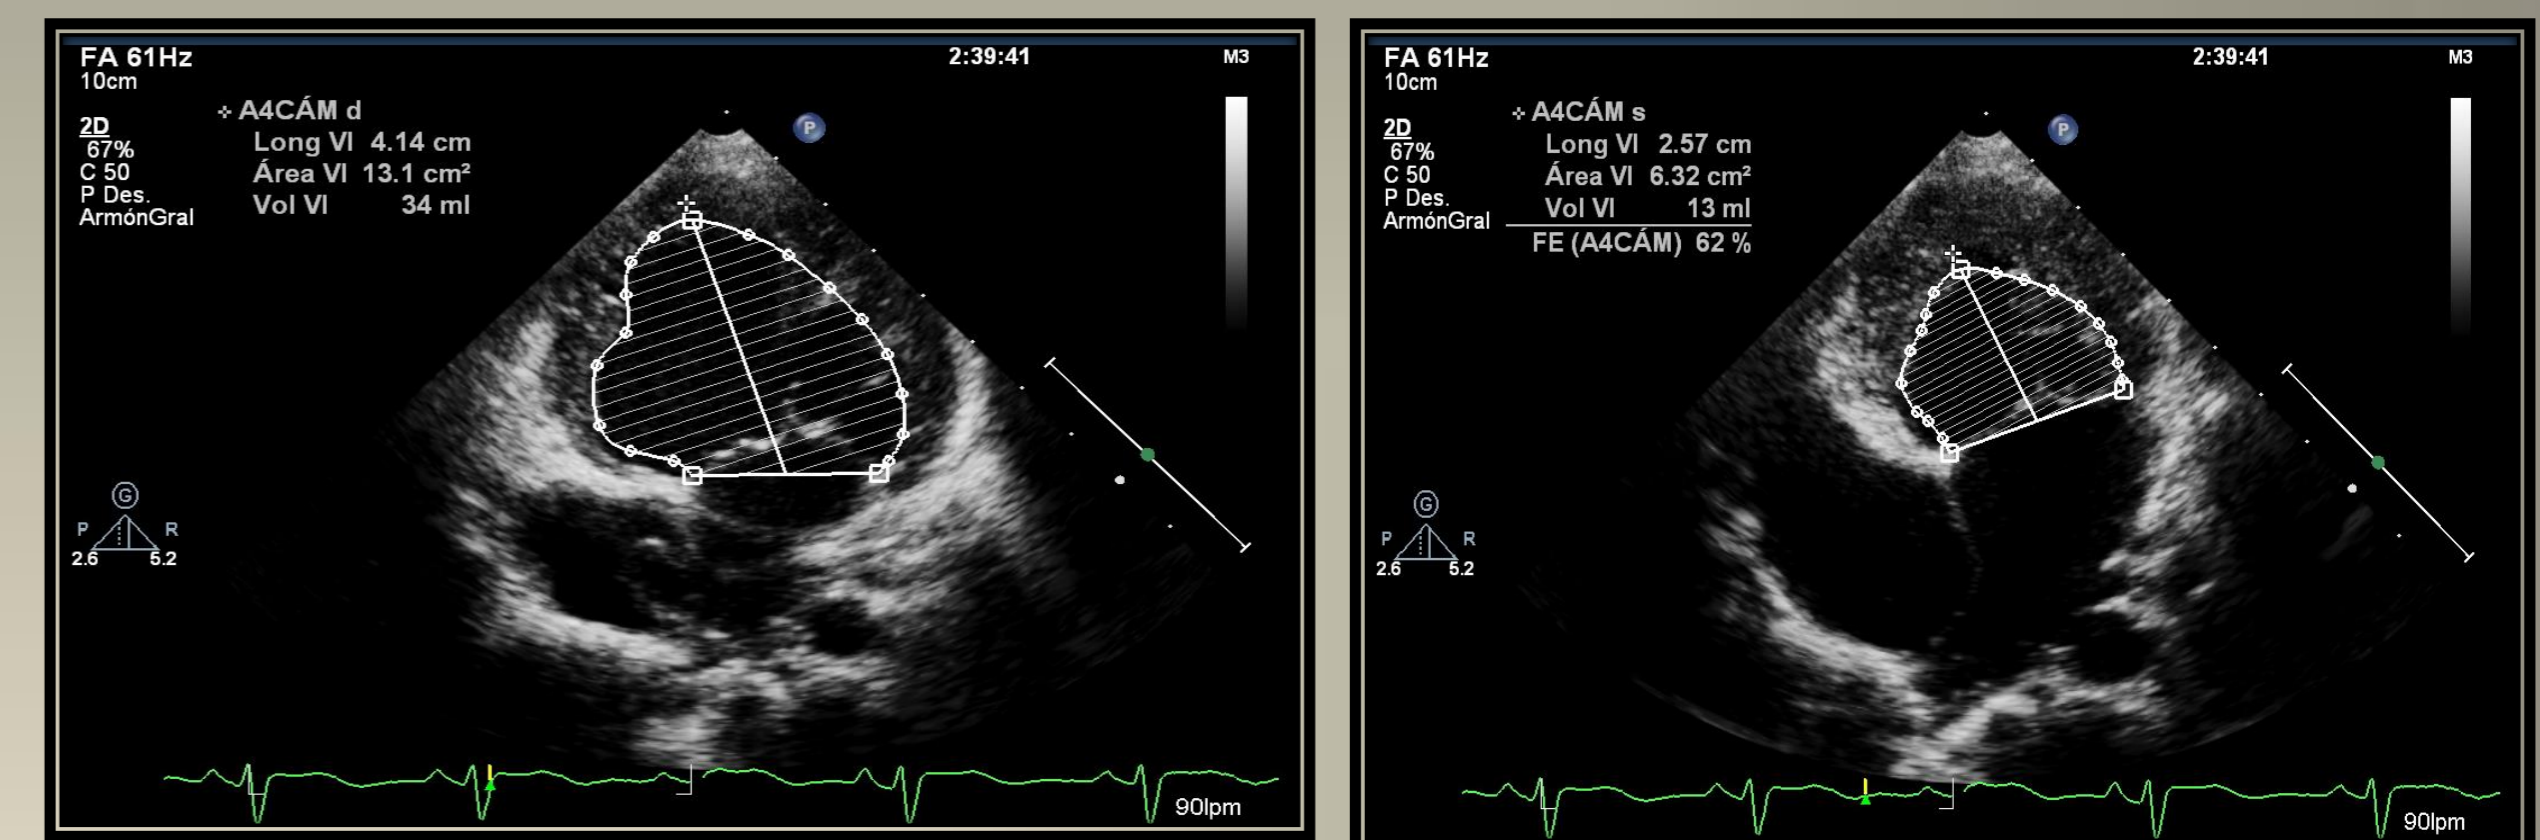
2D Echocardiography. Evaluation EF. Determining the Diastolic and Systolic Volume (Main ventricle left morphology)
